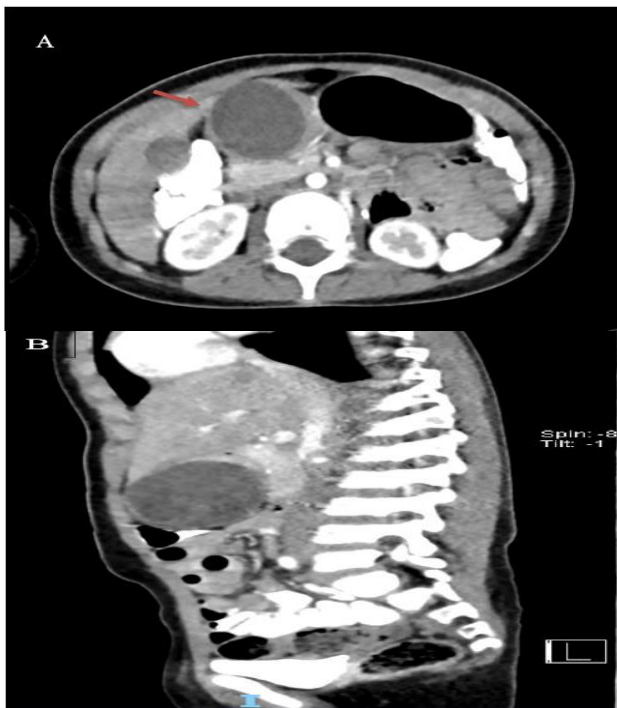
(A and B): CT showed cystic mass compressing duodenum and stomach. Transverse plane and Saggital plane.
